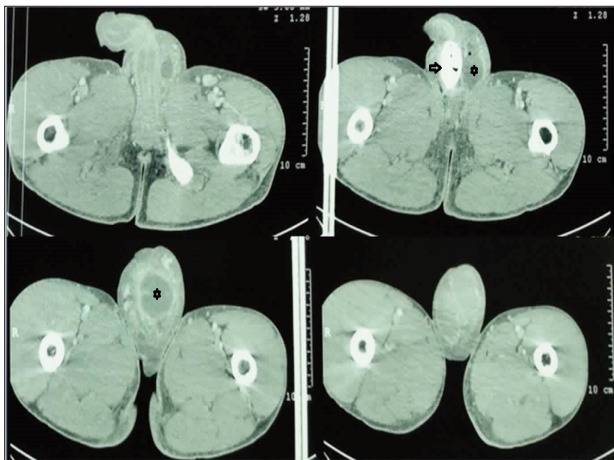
CT scan showing a large anterior urethral calculus (arrow) with a peri-urethral rim-enhancing fluid collection (star).
